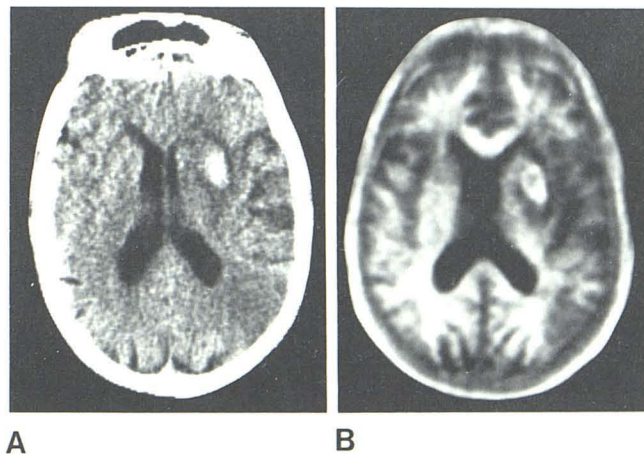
Hemorrhagic infarction. A, CT. B, IR_{1400/400}. Area of hemorrhage displays short T₁ rim with longer T₁ center. Additional areas of infarction are noted.
